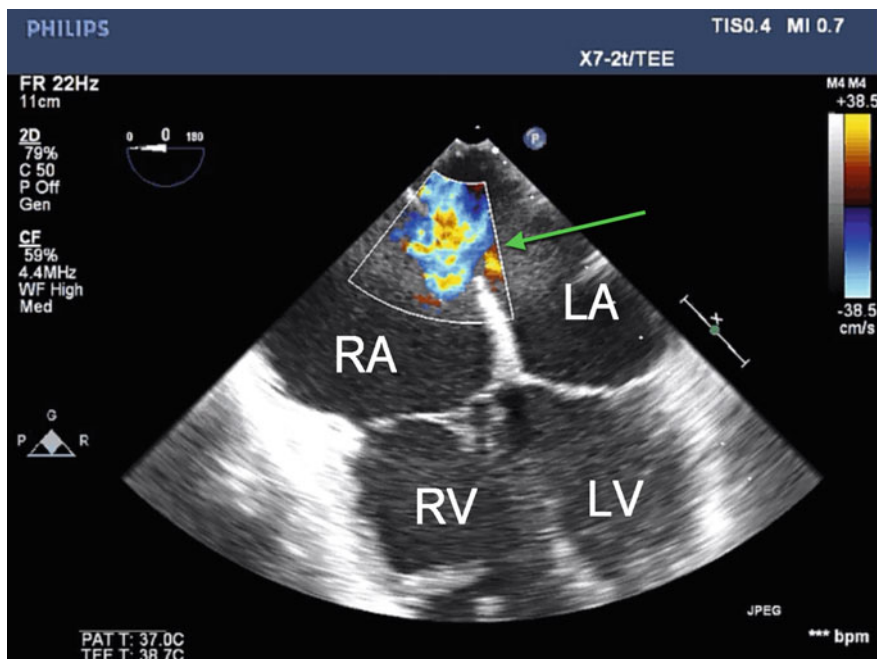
Midesophageal four chamber view demonstrating an ostium secundum ASD (*green arrow*) with left to right flow noted on color flow Doppler. RA right atrium; LA left atrium; RV right ventricle; LV left ventricle
